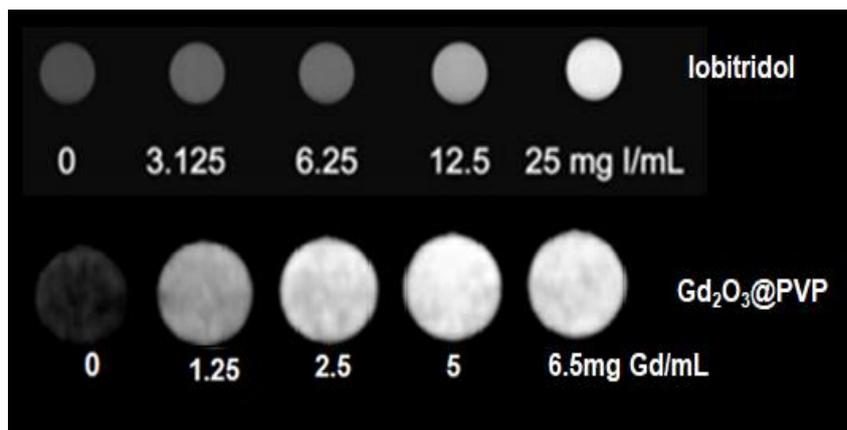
CT scan using commercial Iobitridol and synthetic  $Gd_2O_3@PVP$  at 200 °C for 6 hours.
